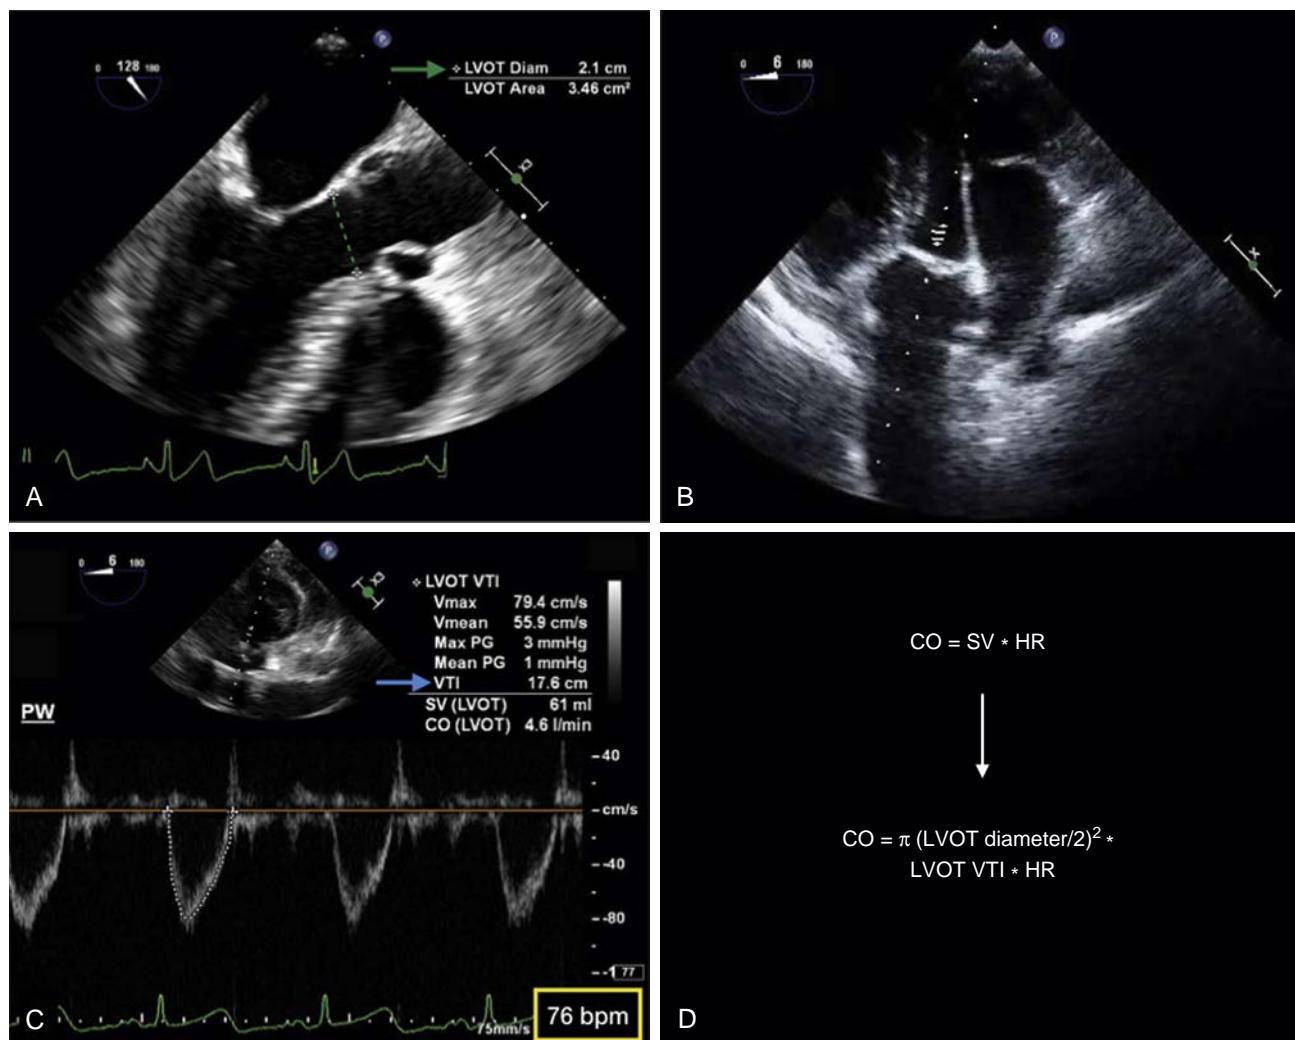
Calculation of cardiac output (CO) using transesophageal echocardiography. (A) The left ventricular outflow tract (LVOT) diameter is measured in the midesophageal aortic valve long axis view. The cross-sectional area (CSA) of the LVOT is assumed to be circular, and is calculated as: $CSA_{LVOT} = \pi \left(\frac{LVOT \text{ Diameter}}{2} \right)^2$. In this example, $CSA_{LVOT} = 3.14 * \left(\frac{2.1 \text{ cm}}{2} \right)^2 = 3.46 \text{ cm}^2$. (B) Velocity of blood flow through the LVOT is measured using pulsed-wave Doppler in the deep transgastric view. The velocity and diameter measurements should be performed at the same anatomic location. (C) The spectral envelope is traced to determine the area under the curve, which is equal to the velocity time integral (VTI). This represents the distance the column of blood travels with each beat and is sometimes referred to as "stroke distance." Stroke volume (SV) is the product of the cross-sectional area of the LVOT and the LVOT VTI, or $SV = CSA_{LVOT} * LVOT \text{ VTI}$. (D) CO is derived by multiplying the stroke volume (SV) by heart rate (HR), or $CO = 3.46 \text{ cm}^2 * 17.6 \text{ cm} * 76 \text{ bpm} = 4,628 \frac{\text{ml}}{\text{min}}$. In the example provided, the machine is configured to automatically calculate stroke volume and cardiac output as displayed in panel C.
